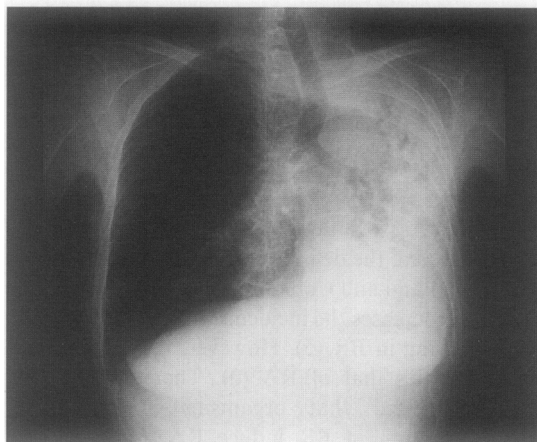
Chest X-ray film at the time of reference to our department. The entire left lung showed destruction and atrophy. Left deviation of the trachea was observed.
